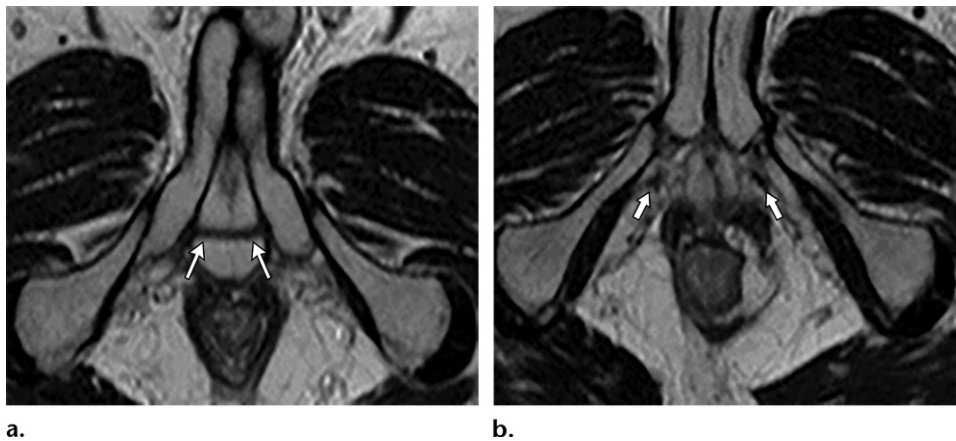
Urethral sling in a 70-year-old man. Axial T2-weighted MR images show the appropriate position for the urethral sling (arrows). A normal urethral sling is thin and hypointense on T2-weighted MR images and extends laterally into the obturator foramina.
